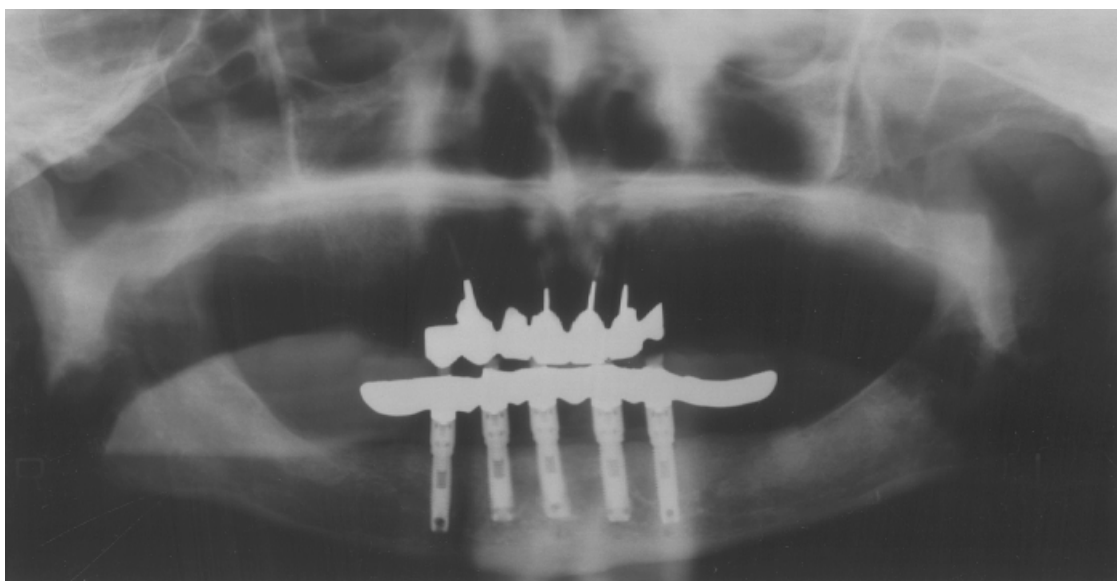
Radiograph of a patient with a fully edentulous mandibular jaw treated using the method recommended by Brånemark. Five implants are installed between the mental foramina to support an implant-anchored fixed full prosthesis.
